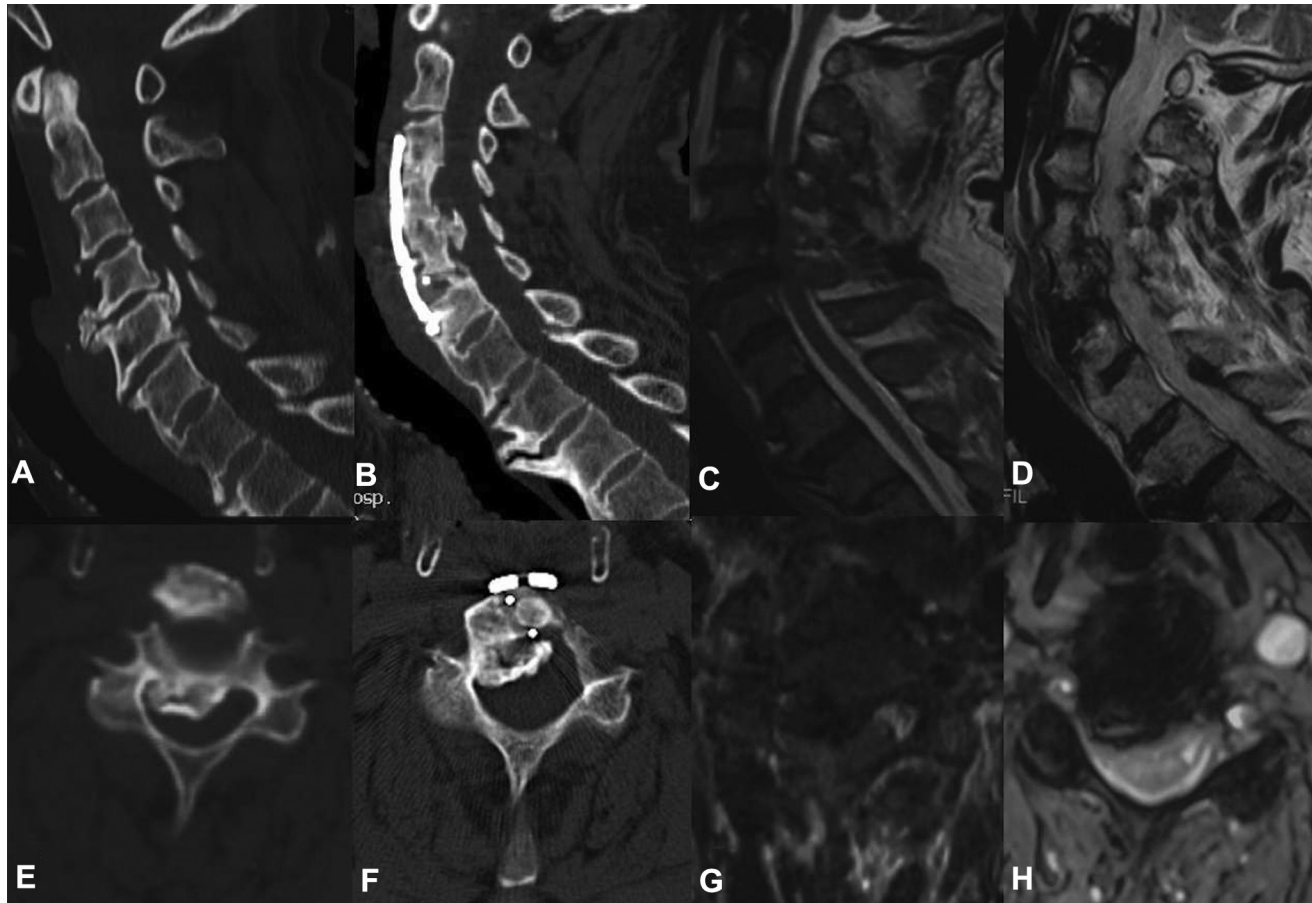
Radiologic data of case 1. (A) Preoperative sagittal CT scan showed ossification of the posterior longitudinal ligament from C4 to C5. (B) Postoperative sagittal CT scanning showed antedisplacement of the VOC from C4 to C5 and the PROM at C4/5. (C) Preoperative sagittal MRI showed compression of the spinal cord from C4 to C5 caused by OPLL. (D) Postoperative sagittal MRI showed insufficient antedisplacement of OPLL at levels C4 and C5. (E) Preoperative cross-sectional CT scanning showed ossification of the posterior longitudinal ligament at C4. (F) Postoperative cross-sectional CT scanning showed antedisplacement of the VOC at the C4 level with postoperative remaining ossification mass in the spinal canal. (G) Preoperative cross-sectional MRI showed compression of the spinal cord at C4 caused by OPLL. (H) Postoperative cross-sectional MRI showed remaining compression in the spinal cord at the C4 level. CT, computed tomography; MRI, magnetic resonance imaging; OPLL, ossification of the posterior longitudinal ligament; PROM, postoperative remaining ossification mass; VOC, vertebrae-OPLL complex.
